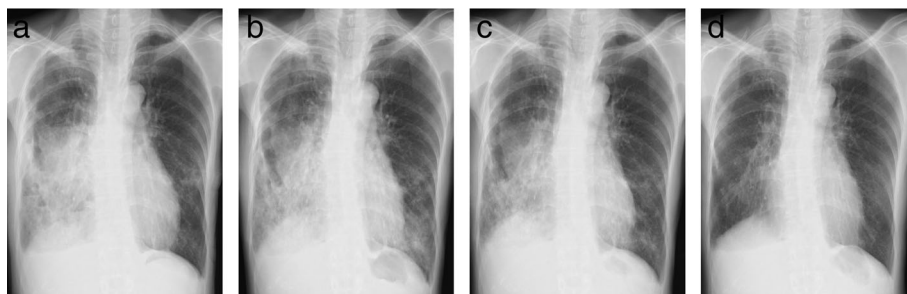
(a) Chest X-ray revealed new reticular opacities in the left lower lung field, as well as postsurgical pleural effusion and infiltrates in the right lung field eight days after right middle partial resection. (b) The reticular opacities in the left lower lung field worsened 15 days postoperatively. (c) Following steroid pulse therapy, the opacities had slightly reduced. (d) All findings improved after oral corticosteroid therapy over five months.
